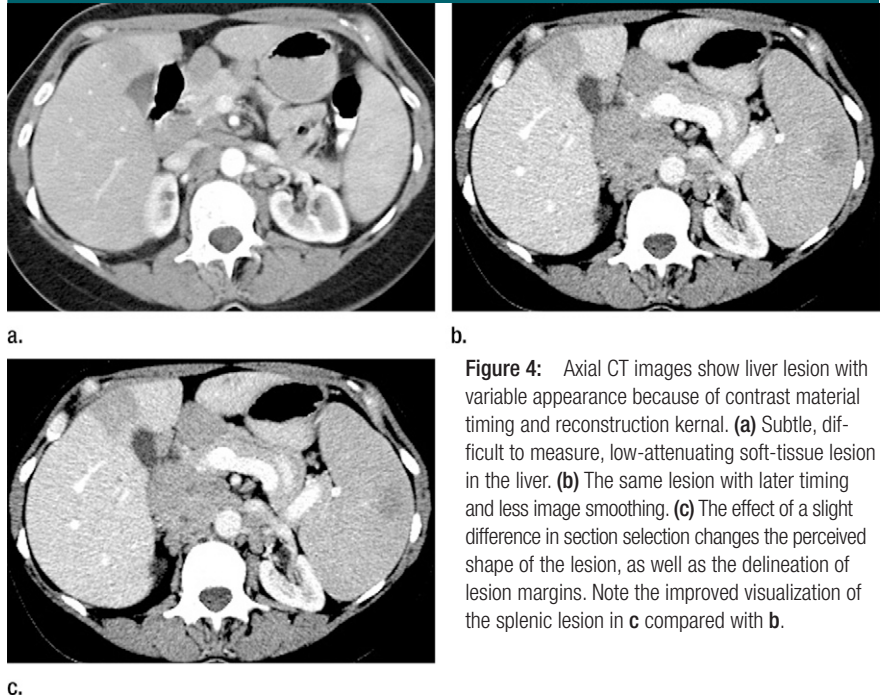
Axial CT images show liver lesion with variable appearance because of contrast material timing and reconstruction kernel. (a) Subtle, difficult to measure, low-attenuating soft-tissue lesion in the liver. (b) The same lesion with later timing and less image smoothing. (c) The effect of a slight difference in section selection changes the perceived shape of the lesion, as well as the delineation of lesion margins. Note the improved visualization of the splenic lesion in c compared with b.
